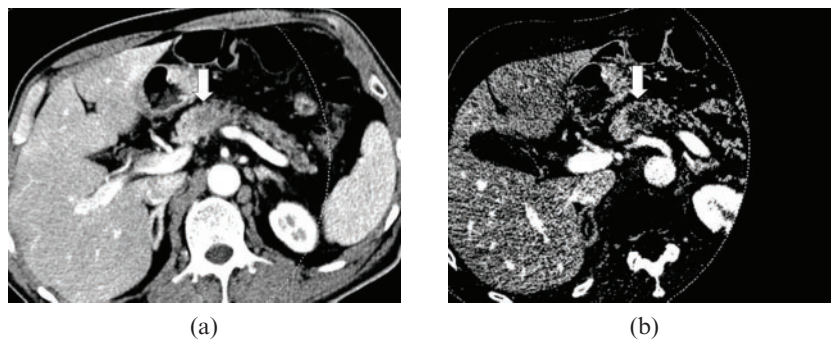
55-year-old male with pancreas body adenocarcinoma. (a) The axial CT scan with a weight factor 0.3 shows an ill-defined, low-attenuation lesion (arrow) in the pancreas body. (b) The iodine map shows much better lesion conspicuity compared with the mixed image, due to the higher lesion-to-pancreas contrast.
